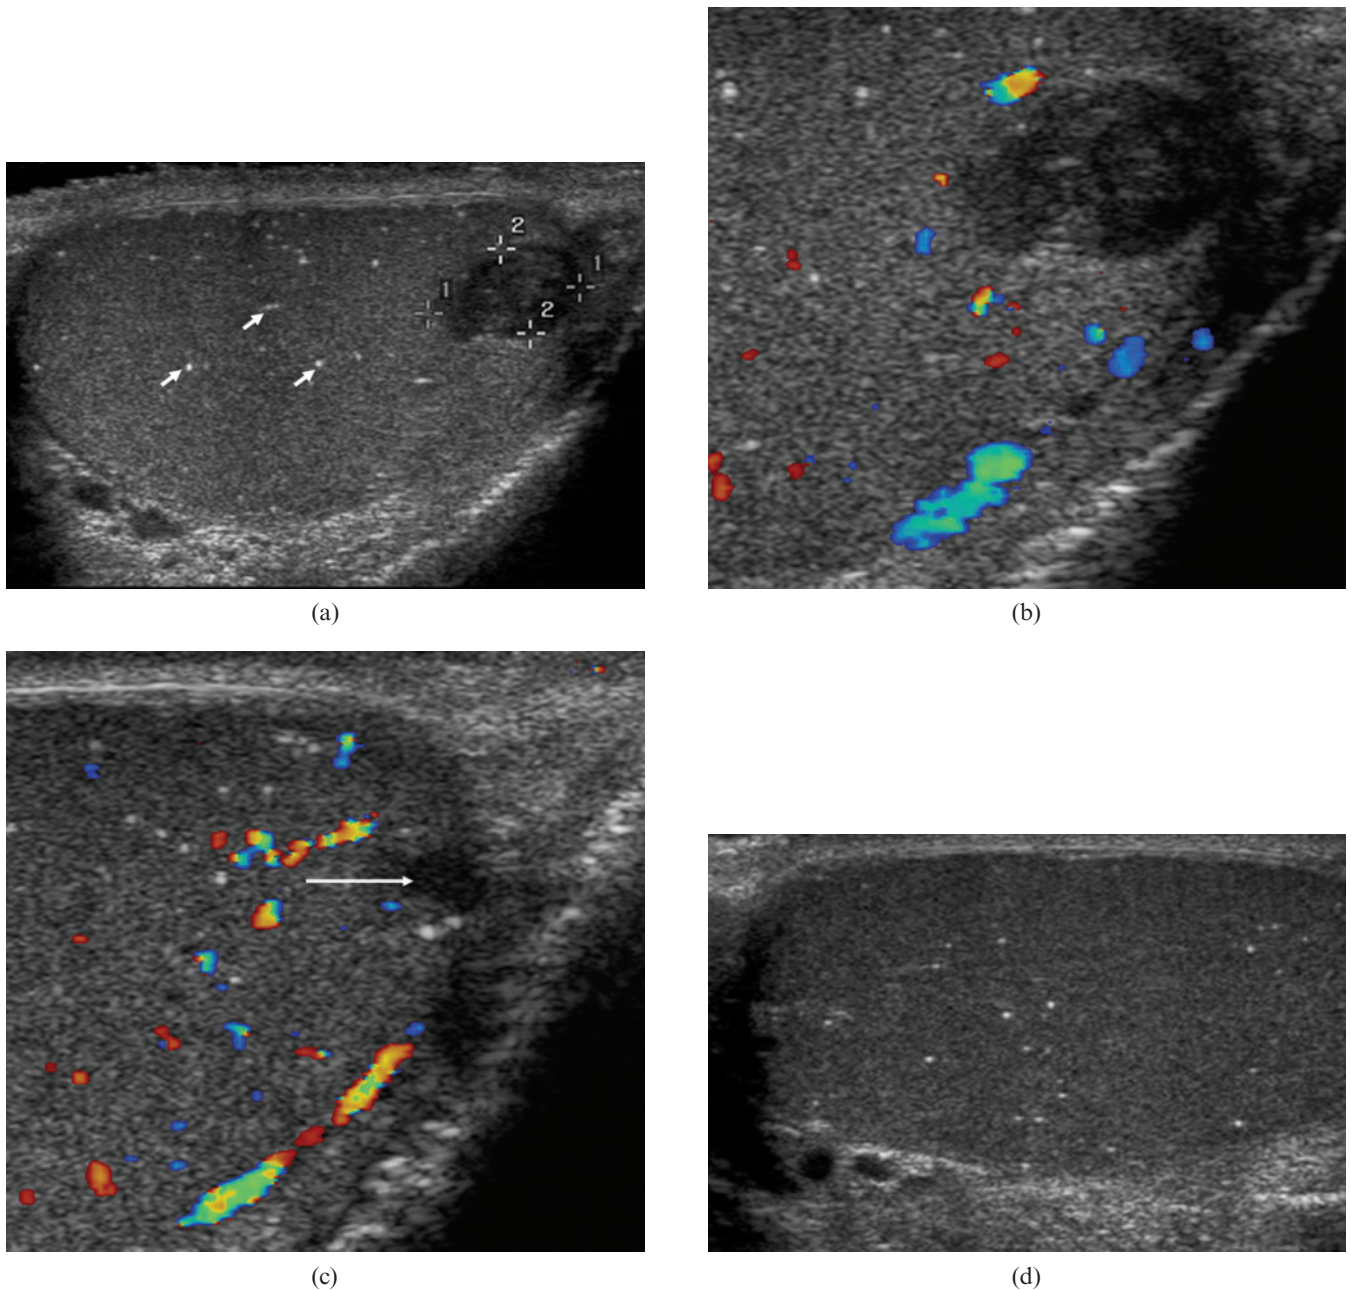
(a) Longitudinal image of the left testis demonstrating a focal area of low reflectivity (between cursors) with internal echoes, and widespread microlithiasis (arrows). (b) Colour Doppler image, on optimal low flow sensitivity, of the lesion demonstrating no internal colour Doppler signal within the low reflective areas. Internal echoes are again demonstrated. (c) At 4 weeks there has been reduction in size of the lesion (arrow), with no internal colour Doppler signal present. (d) 1 year later, there is no abnormality present in the left testis at the site of the previous lesion; microlithiasis remains.
